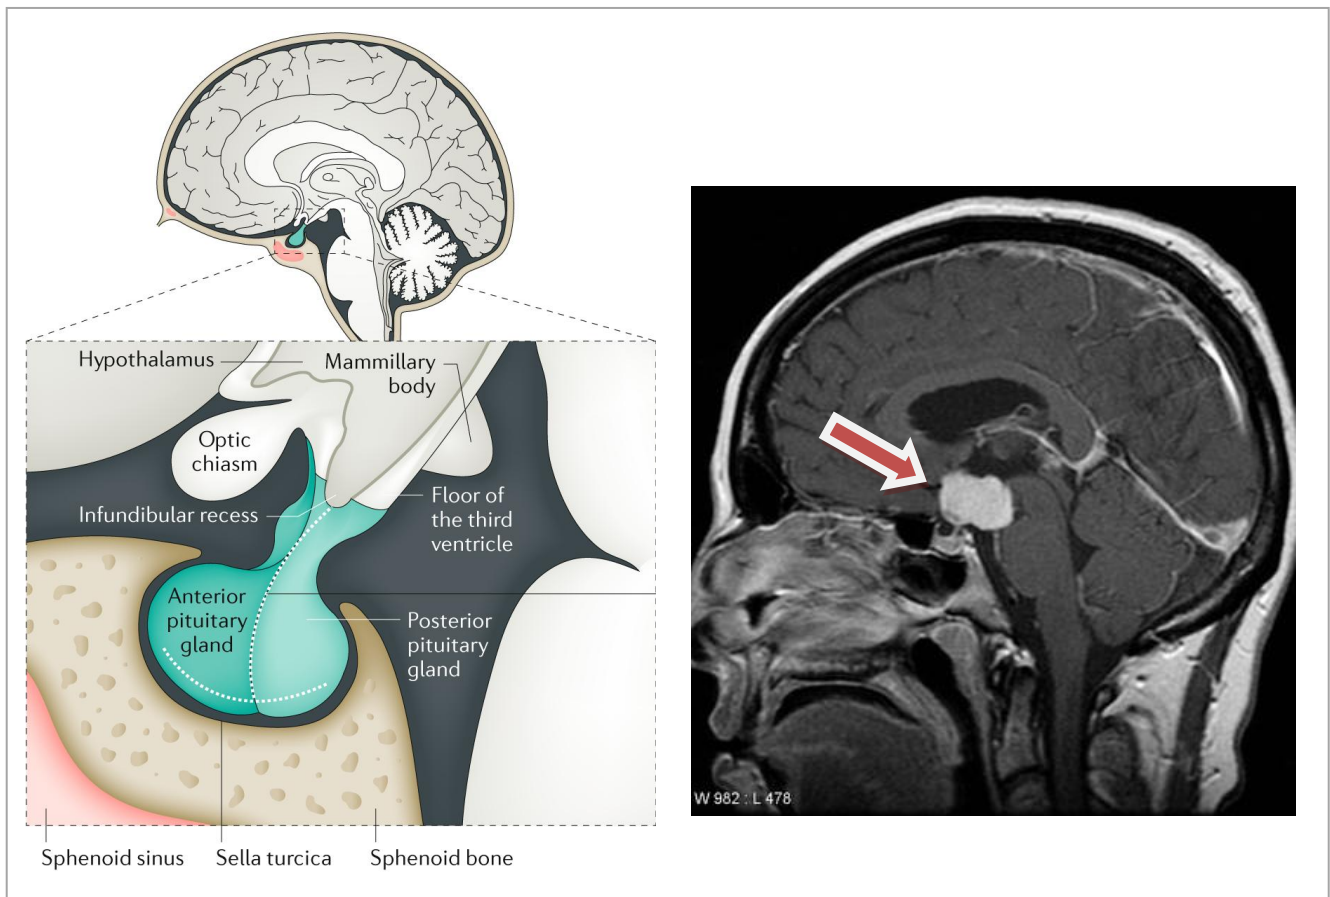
On the left: anatomical sketch of sellar region and the respective structures potentially affected by CP (adapted from Müller et al¹⁵); on the right: sagittal T1-MRI of a case example with papillary craniopharyngioma¹⁶.
